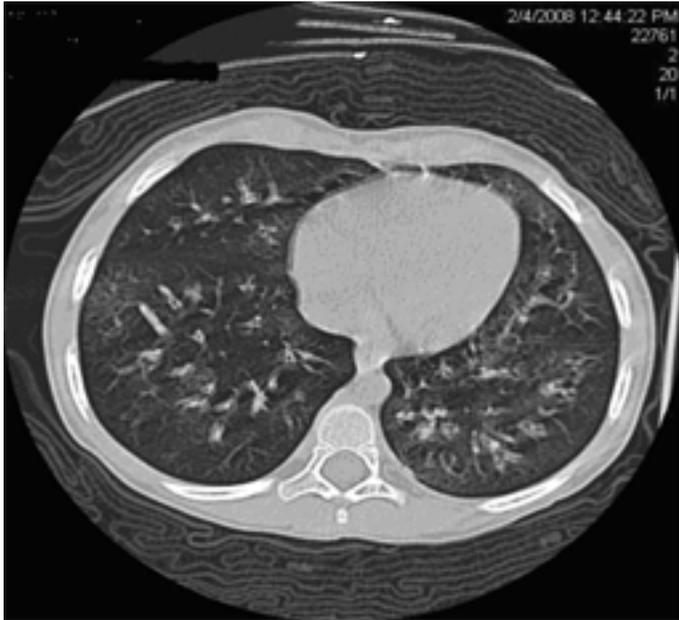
CT of the Chest
